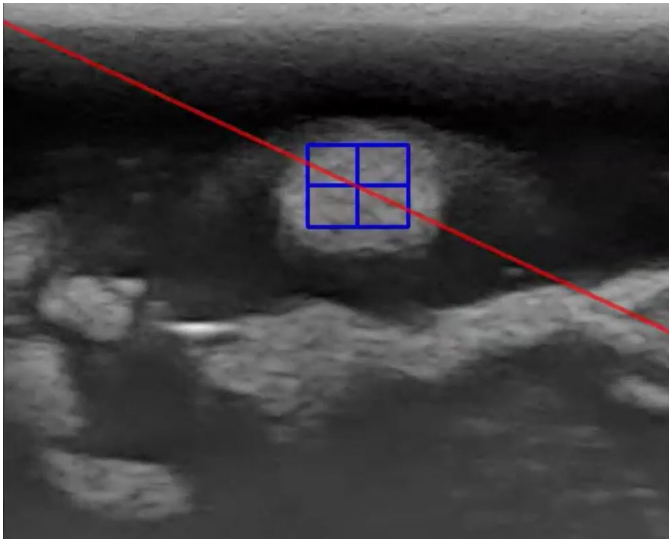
Ultrasound frame of the first test using Mean Shift. The red line indicates the needle path and the blue box with the cross indicates the ROI with the CoM. This tumor was also used for the CamShift tests.
